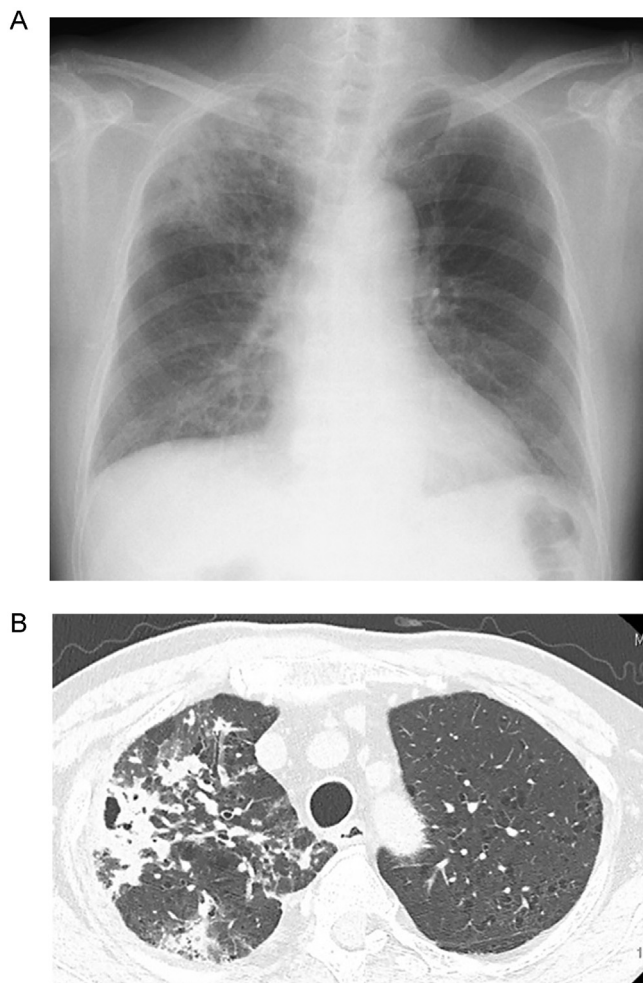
(A) Chest X-ray shows consolidation in the right upper lung field and ground glass opacity in the bilateral lung bases. (B) Chest computed tomography shows emphysema, consolidation and granular shadows in the right upper lobe.
